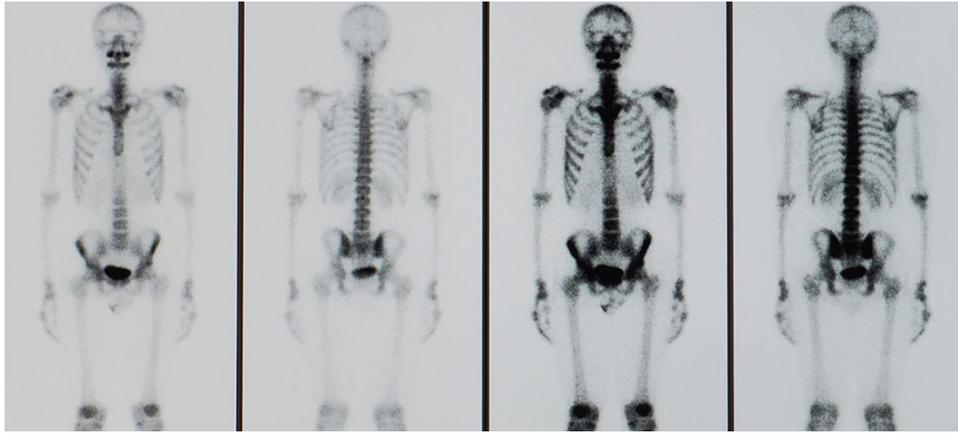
Formation of an image in scintigraphy
